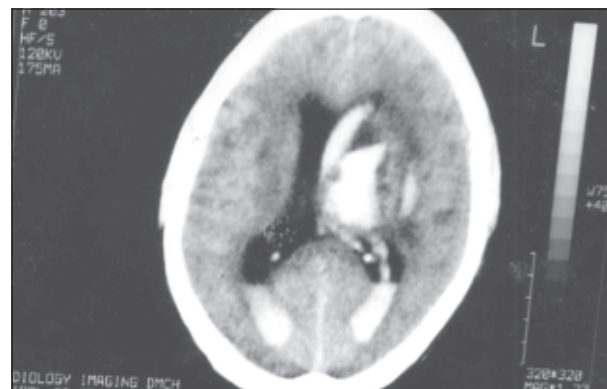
CT-Scan of brain showing left parietal paraventricular heamatomata at left MCA territory with ventricular extension.
